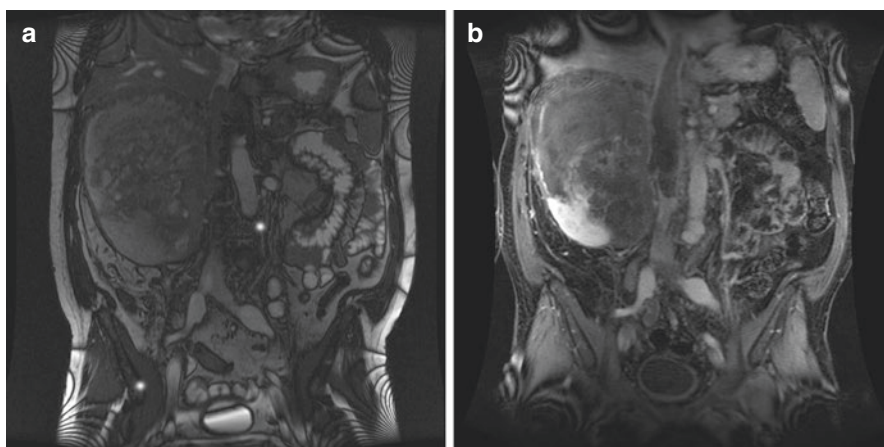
Potential for rapid venous tumor thrombus progression. Images (a) and (b) were taken 20 days apart in a patient with a right renal mass and venous tumor thrombus prior to surgery. A contrast-enhanced MRI is recommended within 7–10 days of surgery. (By permission of Mayo Foundation for Medical Education and Research. All rights reserved)
